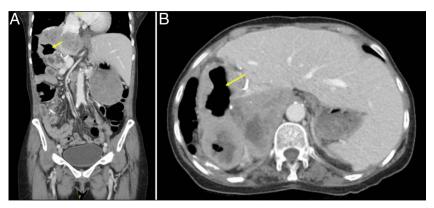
(A) Coronal view of an abdominal-pelvic computed tomography (CT) scan demonstrating fluid and gas-filled component at the expected location of the right hepatic lobe concerning for fistulization with the proximal small bowel (arrow). (B) Axonal view of the abdominal-pelvic CT scan demonstrating fluid and gas-filled component at the expected location of the right hepatic lobe concerning for fistulization with the proximal small bowel (arrow).
